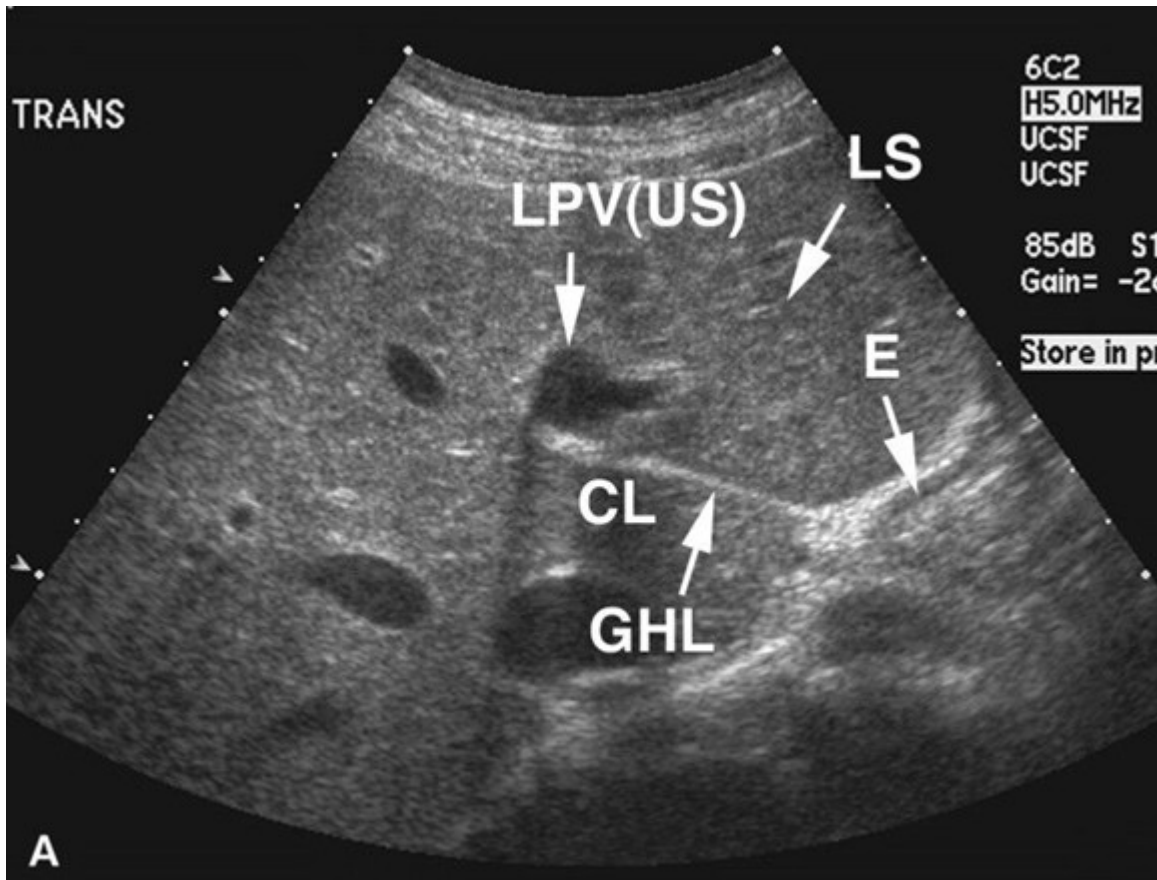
show transverse ultrasonogram high in the abdomen in which the caudate lobe(CL) and its bordering landmarks can be seen.the left anterior margin of the left lobe is sharply separated from the lateral segment of the left lobe(LS) by the intervening fissure of the ligamentum venosum(GHL), LPV= left portal vein, E= distal esophagus near the stomach.
